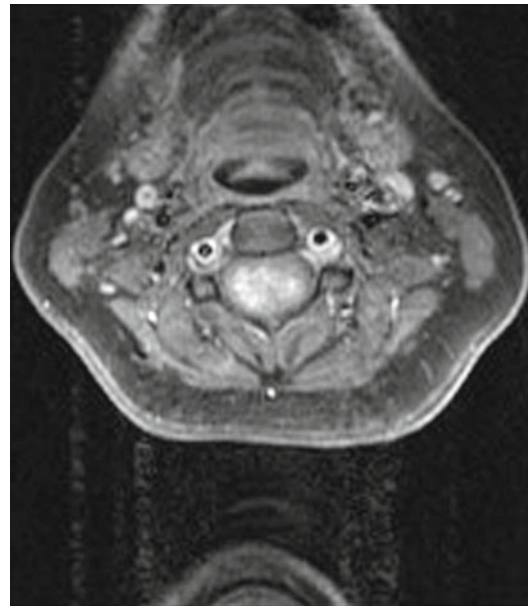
T1-weighted MRI with contrast enhancement depicting an ependymoma
